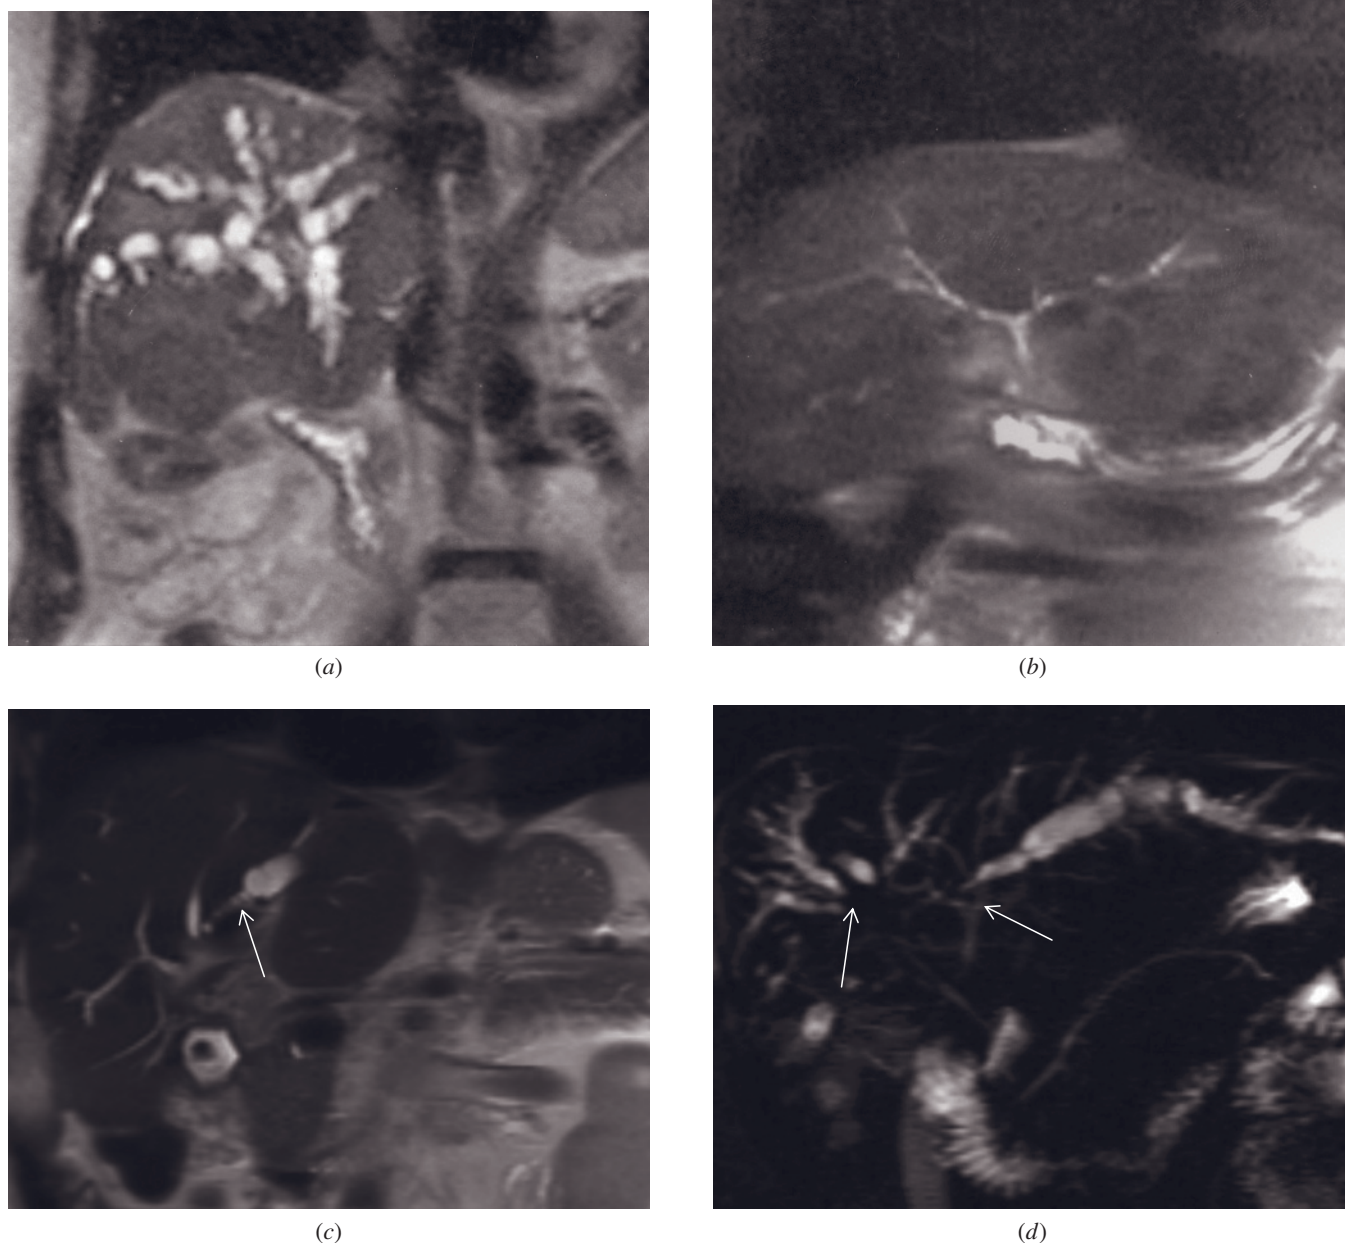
Primary sclerosing cholangitis (PSC), beading. Coronal T2-weighted single-shot echo-train spin-echo images without (a) and with (b) fat suppression in two different patients (a, b, respectively). The high-signal intrahepatic bile ducts demonstrate beading caused by short strictures alternating with dilated (a) or normal-caliber (b) segments. Coronal T2-weighted single-shot echo-train spin-echo (c), coronal thick-section fast spin-echo MRCP (d), transverse T2-weighted single-shot echo-train spin-echo
